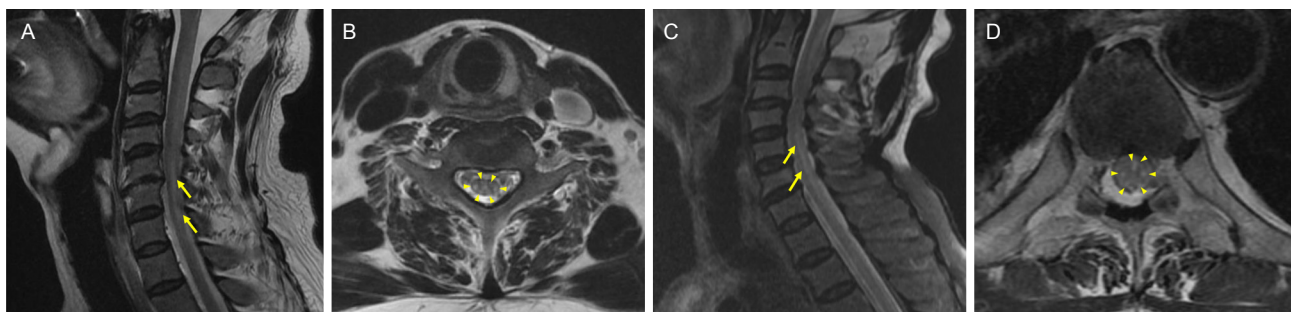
Magnetic resonance imaging images of the spinal cord lesions in two patients. Patient 1, T2-weighted imaging (T2WI) sagittal image of high-signal intensity lesion extends from C4 to C5 (A, arrows), T2WI axial image of bilateral anterior, lateral, and posterior column lesions at C5 level (B, arrowheads); patient 2, T2WI sagittal image of high-signal intensity lesion extends from C5 to C6 (C, arrows), T2WI axial image of bilateral anterior, lateral, and posterior column lesions at T3 level (D, arrowheads).
